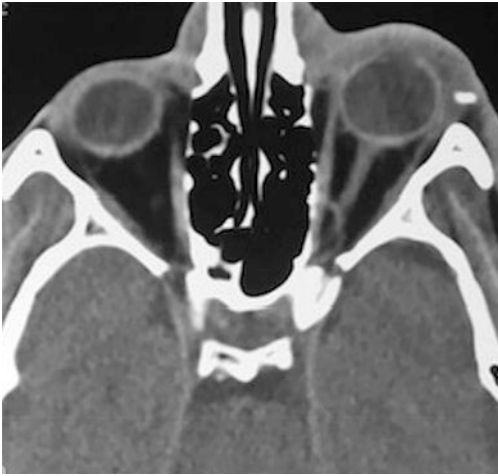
Preseptal orbital Foreign body complicated with inflammatory changes. Axial CT image demonstrate left preseptal foreign body associated with preseptal soft tissue swelling
